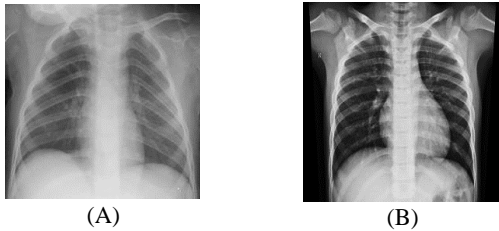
(A) A typical x-ray image from Dataset A and (B) a typical x-ray image from dataset B.
